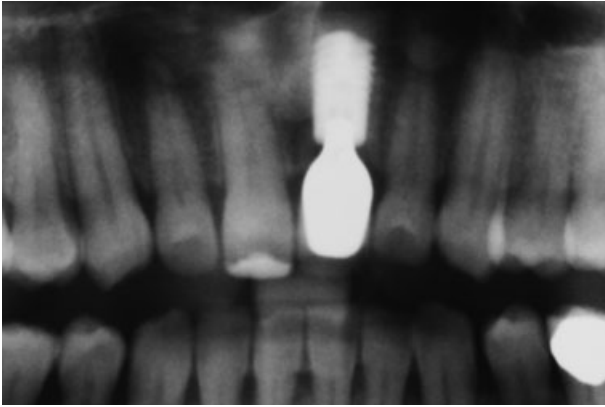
Orthopantomogram taken after final insertion of the implant-retained crown regio 21.
